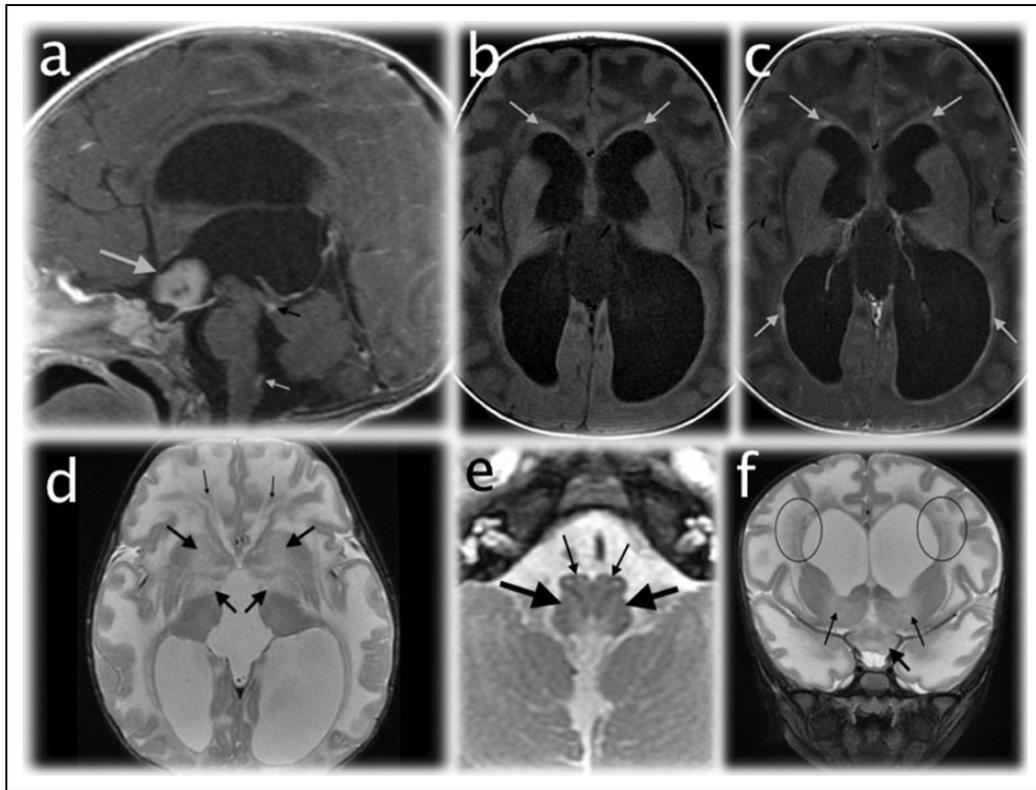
Magnetic resonance imaging brain in Alexander disease affected infant. Postcontrast sagittal SPGR T1 (TR/TE msec, 600/13) (a) demonstrates an enhancing optic chiasmatic mass (large white arrow) and nodular enhancement along the posterior margin of the cerebral aqueduct (small white arrow) and obex (small black arrow). There is aqueductal stenosis and consequent noncommunicating hydrocephalus manifested by marked supratentorial ventriculomegaly, upward bowing of the corpus callosum, and expanded third ventricular recesses. Precontrast (b) and postcontrast (c) axial T1-weighted images (TR/TE msec, 567/10) show intrinsic high signal along the subependymal regions (arrows, b) and abnormal subependymal enhancement (arrows, c). Most of the remaining cerebral white matter is abnormally hypointense, relatively sparing the occipital lobes, consistent with an anteroposterior gradient of white matter disease (b and c). Axial T2-weighted image (TR/TE msec, 3200/90) (d) depicts hyperintense signal in the cerebral deep gray nuclei (large arrows) and hypointense periventricular white matter signal along the frontal horns of the ventricles (small arrows). Axial T2-weighted image (TR/TE msec, 3200/90) (e) through the medulla oblongata shows ill-defined hyperintense signal infiltrating the pyramids and olives (small arrows) and dorsal medulla (large arrows). Coronal T2-weighted image (TR/TE msec, 4450/98) (f) demonstrates a hyperintense chiasmatic mass lesion (large black arrow), signal hyperintensity in the striatum (small arrows), and radially striated hypointense signal in the cerebral white matter (ovals) on the background of more diffuse cerebral white matter hyperintensity and swelling.
